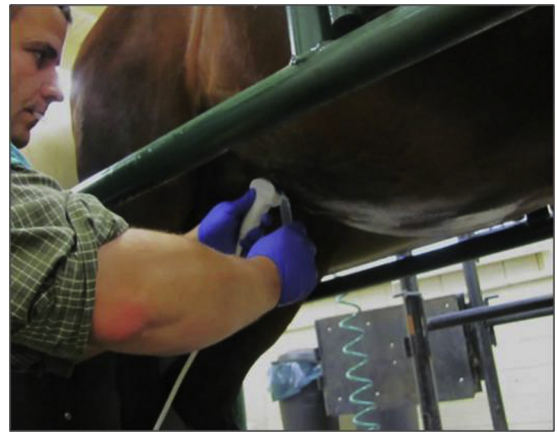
Local lidocaine block guided by ultrasound. Note that the transducer was held where the operator found a readily accessible pocket of fetal fluid.
